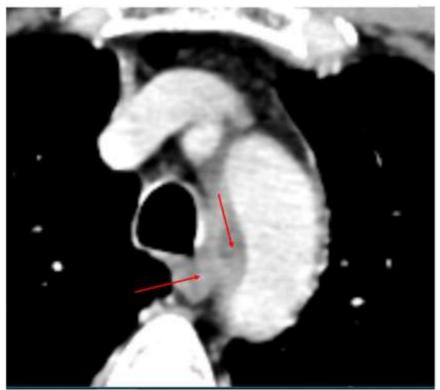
CT Neck Post Contrast at the Aortic Arch Level Showing the Encasement of the Aortic Arch.
